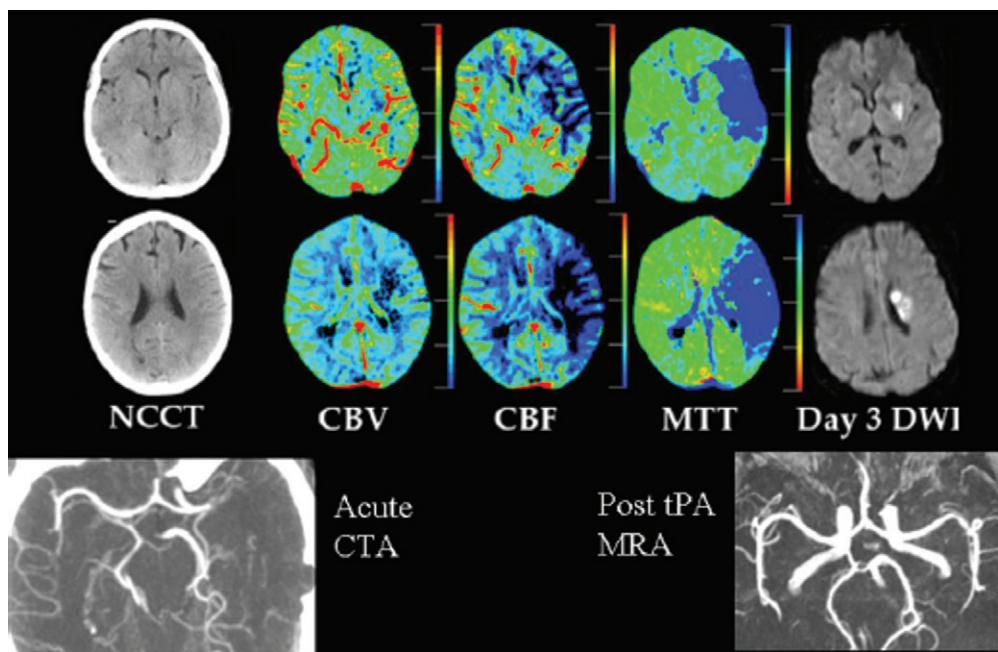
The penumbra on CT perfusion in a patient imaged with multimodal CT at 3.5 hours after stroke onset with National Institute of Health Stroke Scale (NIHSS) 14. M1 occlusion on CT angiography (CTA) (lower left). Small area of reduced cerebral blood volume (CBV) in lentiform nucleus and deep white matter but surrounded by much larger areas of reduced cerebral blood flow (CBF)/prolonged mean transit time (MTT) consistent with ischemic penumbra. Minimal change seen on non-contrast CT (NCCT). Patient treated with intravenous (IV) thrombolysis and had major early neurologic improvement, complete recanalization on follow-up magnetic resonance angiography (MRA) (lower right), and only a small amount of infarction on follow-up diffusion-weighted imaging (DWI) (corresponding to pre-treatment areas of reduced CBV). Original image taken from Ebinger et al. (2009) with permission from Elsevier.
